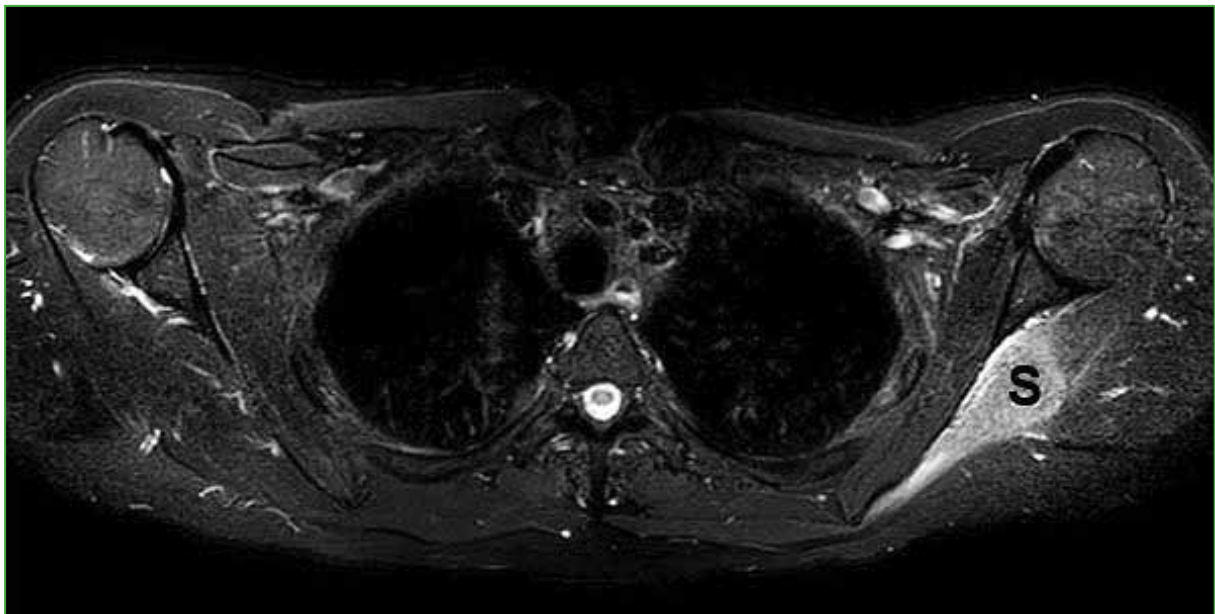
MRI of the left shoulder, axial section, STIR sequence. Edema is observed in relation to the supraspinatus muscle (S).
